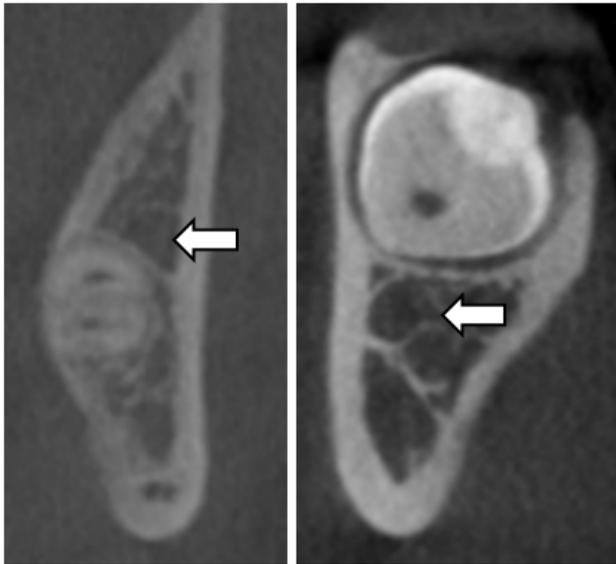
Sagittal section of CBCT showing juxta-apical radiolucency located at apical and cervical third of root of impacted third molar
